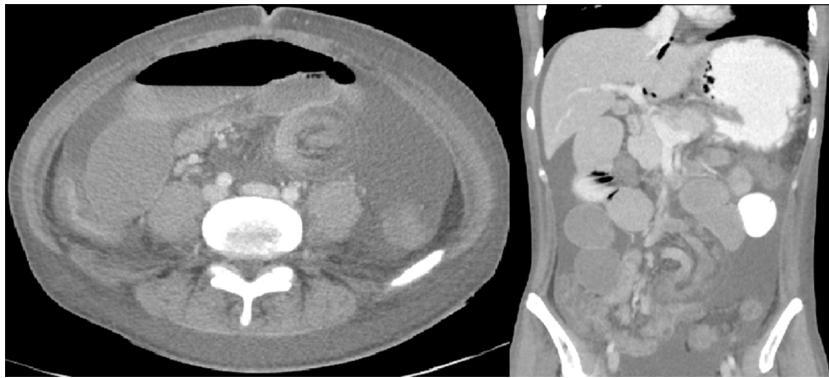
Abdominal CT showing intussusception.
